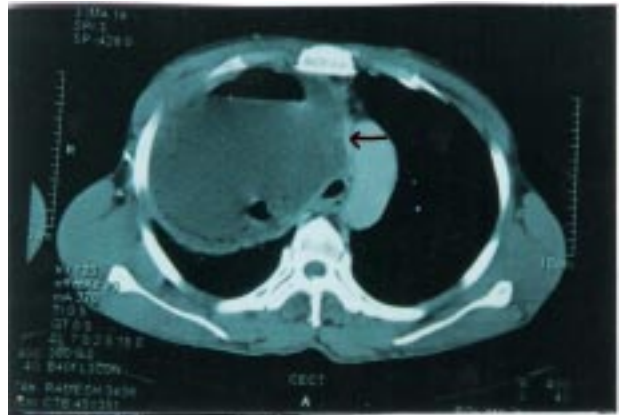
Computed tomographic scan of the chest (mediastinal window) showing lung abscess in right upper zone with compression of superior vena cava (arrow).
